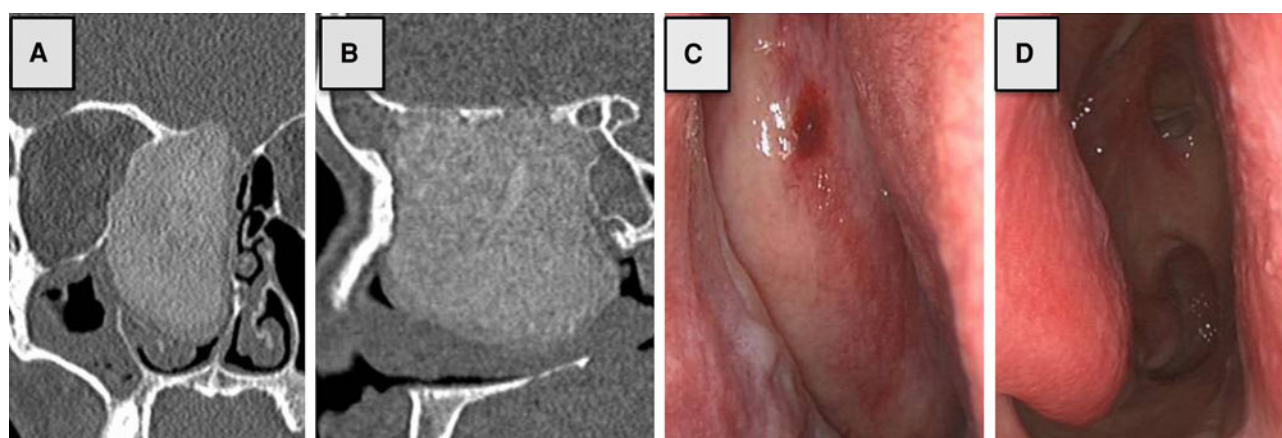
Case 5: The CT-scan shows an extensive, hyperdense and expansive mass in the anterior and posterior ethmoid and the nasal cavity. The medial orbital wall is impressed and there is a wide contact to the skull base. The dura appears to be lifted in some areas
